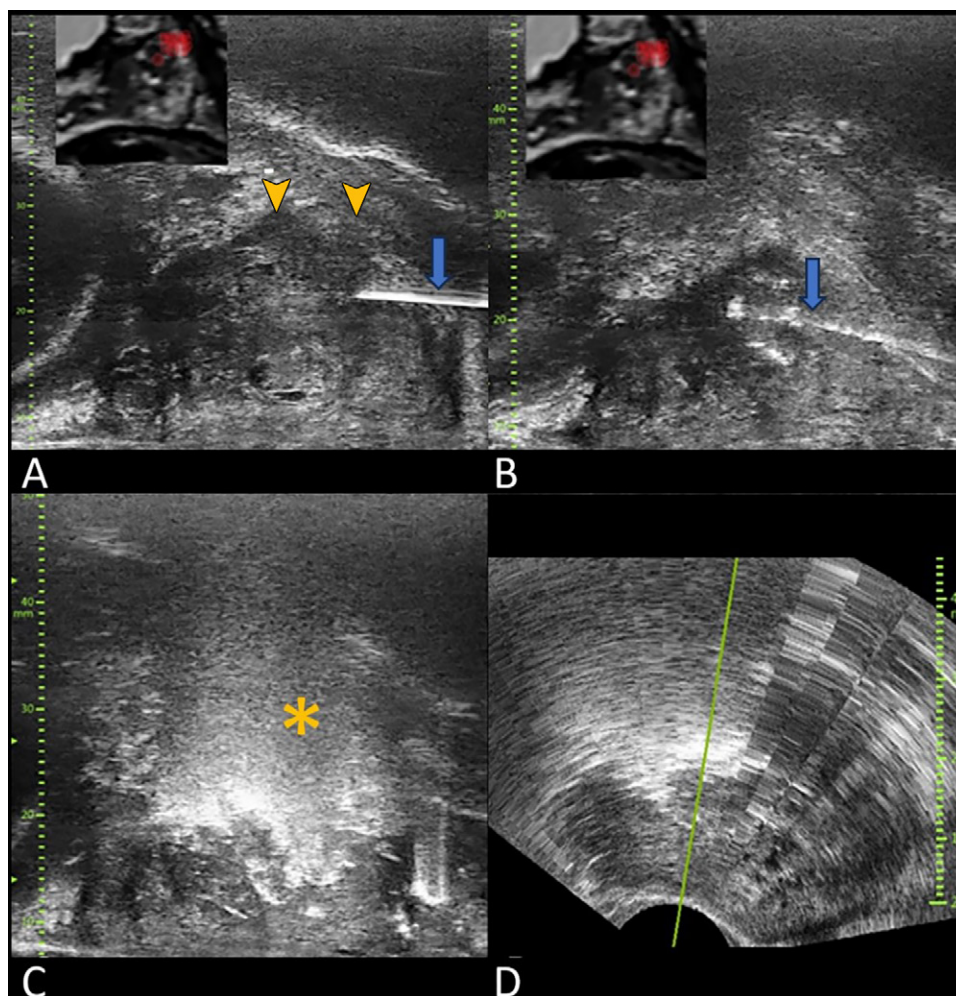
US images show monitoring of focal laser ablation (FLA) in a 62-year-old male participant (initial prostate-specific antigen level, 7.6 ng/mL) with a Prostate Imaging Reporting and Data System (PI-RADS) 4 lesion. (A) Longitudinal image shows placement of a 21-gauge needle (arrow). The PI-RADS 4 lesion is clearly visible (arrowheads), and its location is confirmed by image fusion and is visible on an MRI scan inset in the upper left quadrant of the image. Image fusion (red tags) delineates the limits of the target volume. (B) Longitudinal image shows start of ablation. Laser fiber (arrow) is visible inside the lesion. Several hyperechogenic foci are visible around the laser fiber, indicating that ablation has started. (C) Longitudinal view shows the echogenic area (*), corresponding to gas formation, which indicates that the target volume, visible on MRI fusion scans (top left corners on A and B), has been covered by FLA. The laser fiber is minimally visible. (D) Transverse micro-US reconstruction shows the extent of the ablation zone.
